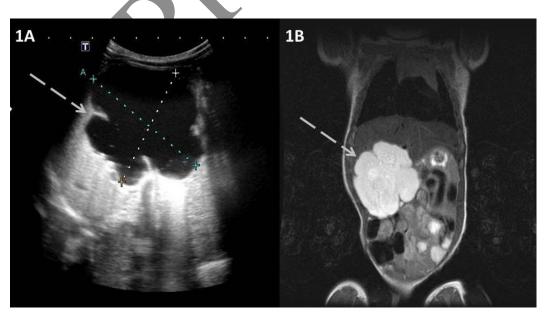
The image of intrahepatic cyst. (A) A multilobulated cystic mass $(6.2 \times 4.8 \times 5.7 \text{ cm})$ within segment V of the liver from abdominal ultrasonogram performed after birth. (B) A multilobulated cystic lesion in the right upper quadrant of the abdomen was noted, measuring $6.2 \times 4.5 \times 5.8$ cm from T1-weighted image of magnetic resonance cholangiopancreatography (MRCP).
